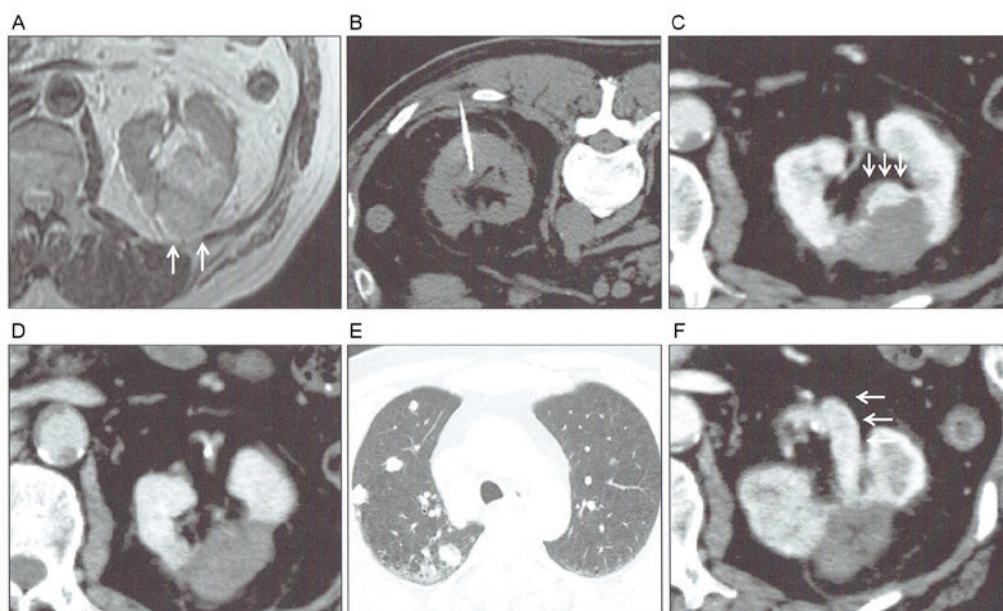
(A) Renal tumor (4.7 cm) located in the lower side of the left kidney. (B) Percutaneous RFA was performed because the patients exhibited multiple comorbidities. (C) CT following three RFA treatments. The residual enhanced lesion (white arrows) remained in the inner side of the kidney. (D) CT 3 months after the fourth ablation. Radiological complete ablation was achieved. (E) Multiple lung metastases and (F) local progression with renal vein tumor thrombus (white arrows) identified by CT 7 months after the final ablation. RFA, radiofrequency ablation; CT, computed tomography.
